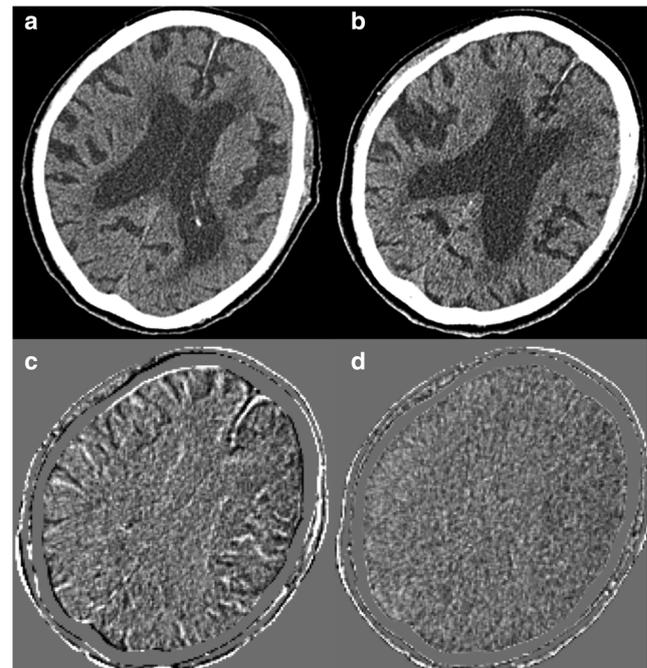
Comparison of two temporal image subtraction techniques: rigid and non-rigid transformations. The (a) previous CT, (b) current CT, (c) TS CT using rigid registration only and (d) TS CT using rigid registration refined with non-rigid registration (in this case, LDDMM) are shown. Rigid transformation and subtraction causes minor misregistrations of the brain sulci, whereas LDDMM and subtraction can cope with these subtle changes and generate better subtraction images
